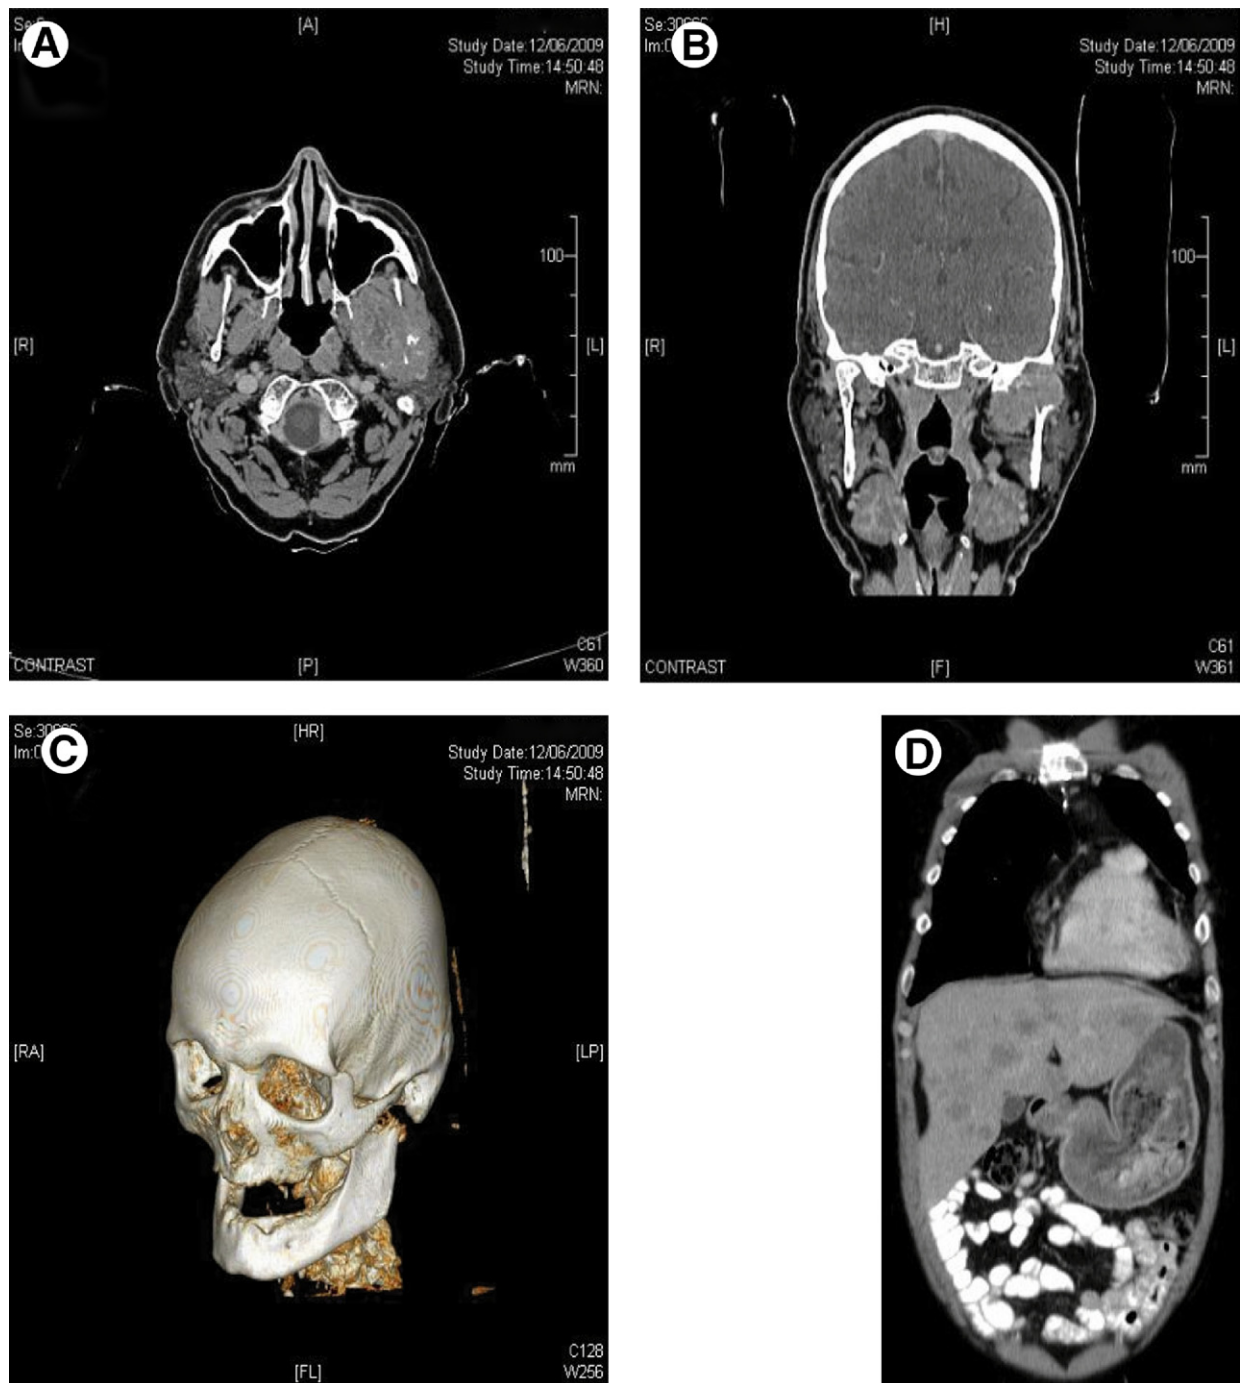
Computed tomography scans of the temporomandibular joint showing the mass and osteolysis of the joint. A, Axial section; B, coronal section; C, 3-dimensional reconstruction; and D, coronal section demonstrating liver metastases.
